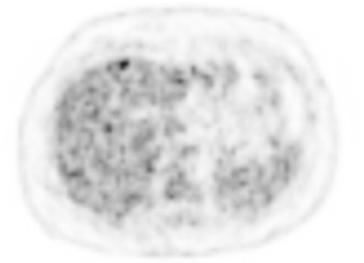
Transaxial CT, PET images. Fifty-one years old patient. 18F-FDG PET imaging was performed for elevated Ca-125 levels (60 U/ml) but recurrence not detected by ceCT. 18F-FDG PET/CT revealed foci in liver.
